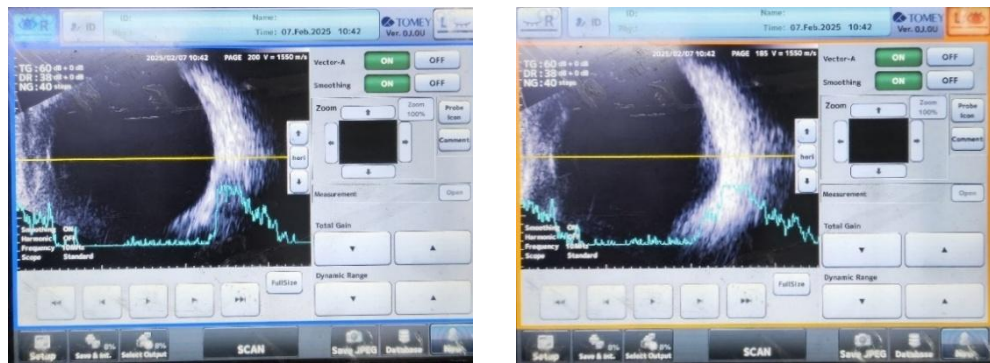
The ultrasound examination of both the right and left eyeballs showed that the eyeball walls were intact and there were no echogenic bands.
